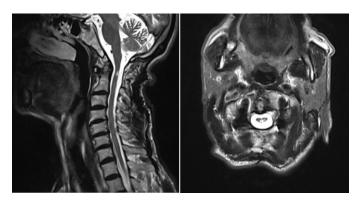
2nd patient post-operative 8th year MRI MRI: Magnetic resonance imaging
